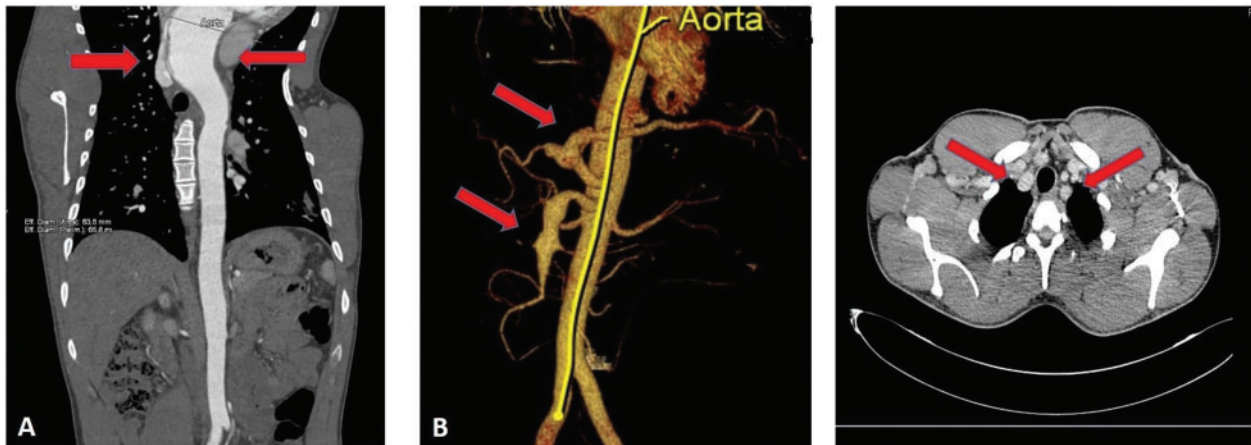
Thoraco-abdominal computed tomography. (A) Ascending aortic aneurysm with a 61-mm maximum diameter in the supravalvular portion (red arrows); (B) aneurysmatic dilatation of the coeliac trunk (18 mm, superior red arrow) and of superior mesenteric artery (19 mm, inferior red arrow); (C) multiple lymph nodes in paratracheal position can be noted (red arrows).
